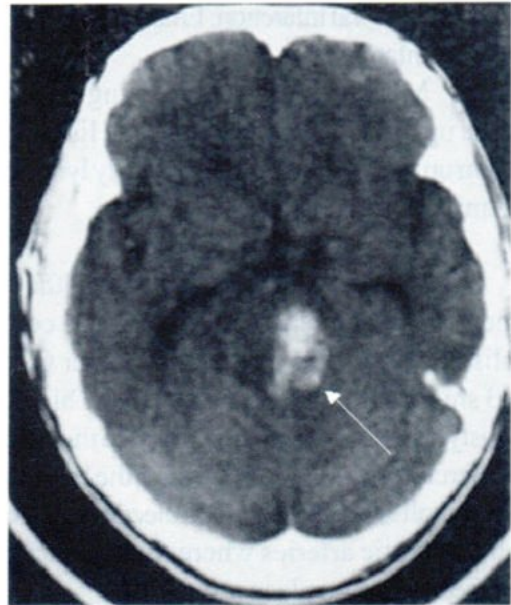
CT. without contrast, a white mass of hematoma is found at the brain stem, at Pons.
